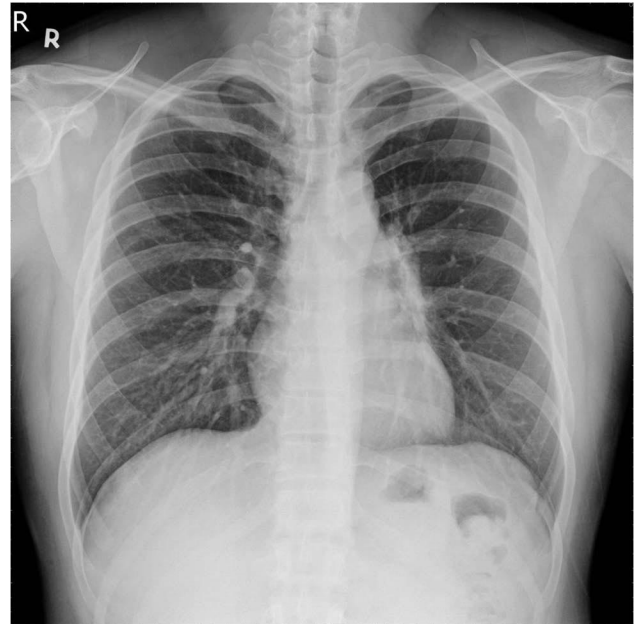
Chest x-ray image demonstrating prominence of the left hilum of the lung.
